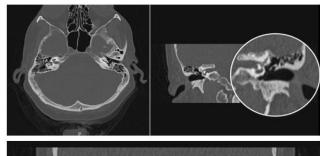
Computed tomography (axial view) with thin cuts of the temporal bone revealed well-pneumatized mastoid regions without any density or secretion and normal middle ears without any density or secretion.
